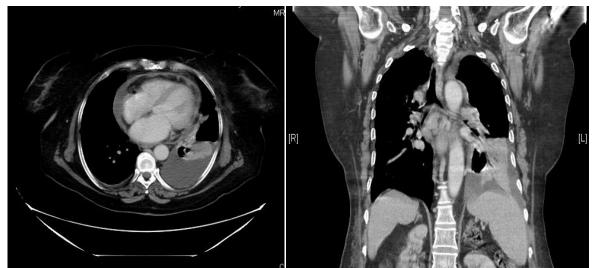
CT chest with contrast showing the pericardial effusion, segmental atelectasis left lower lobe with effusion.Note the lymphadenopathy on CT.
